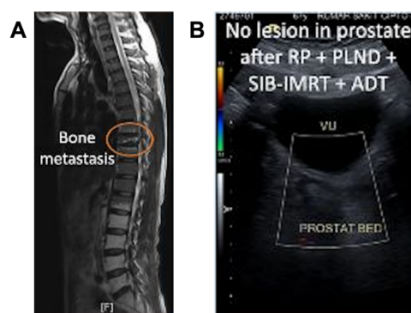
Imaging evaluation. Metastasis in the T9 vertebral body is shown in a contrast-enhanced MRI (A). Abdominal ultrasound examinations conducted after radical prostatectomy (RP), pelvic lymph node dissection (PLND), simultaneous-integrated boost intensity-modulated radiation therapy (SIB-IMRT), and androgen deprivation therapy (ADT) showed no focal pathological lesions in the prostate bed.
